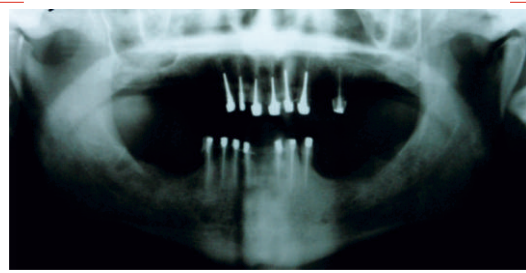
Panoramic radiograph presenting the pre prosthetic treatments.
